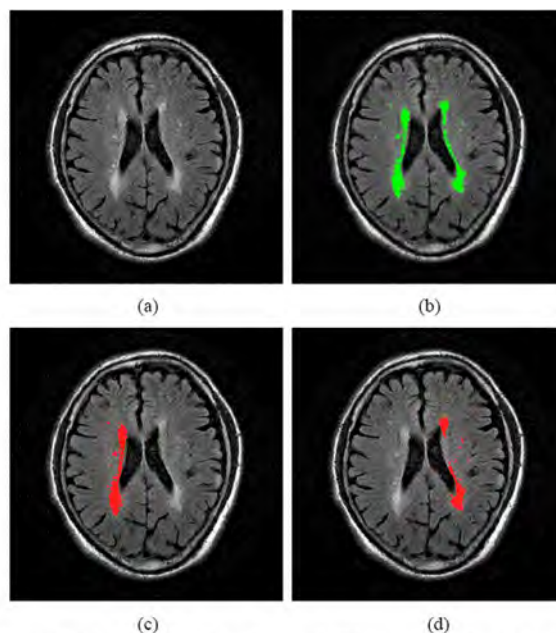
Fig (a) Original FLAIR weighted image (b) White matter lesions detection automatically (c, d) WMLs detection of right and left side by single experienced physician (YWC)
